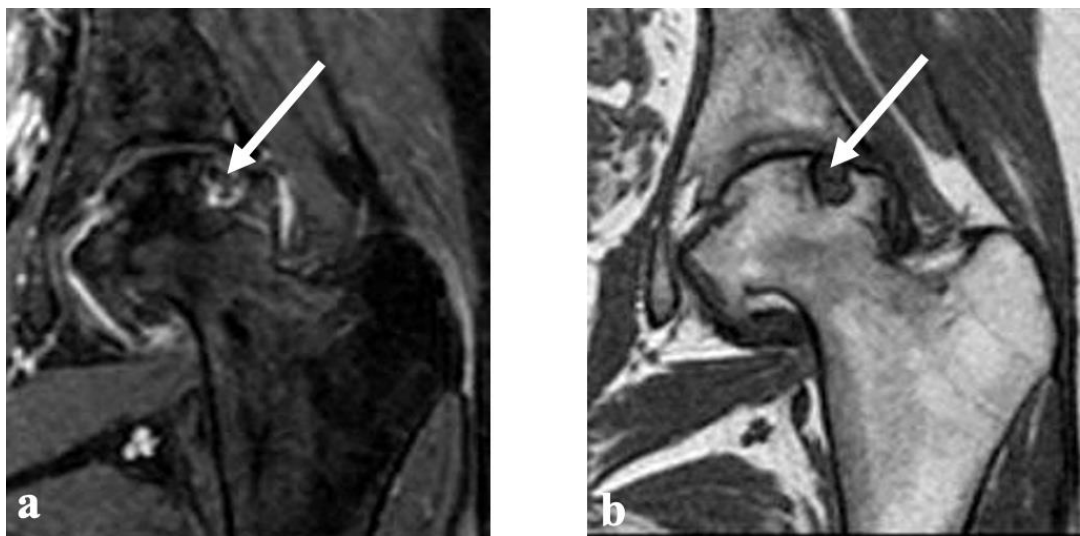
Coronal three-dimensional (3D) fat-saturated T1-w GRE sequence (a) and coronal T2-w FS MRI image (b) in a 15- year-old boy with JIA, showing a moderate (grade 2) overall degree of inflammation.*
